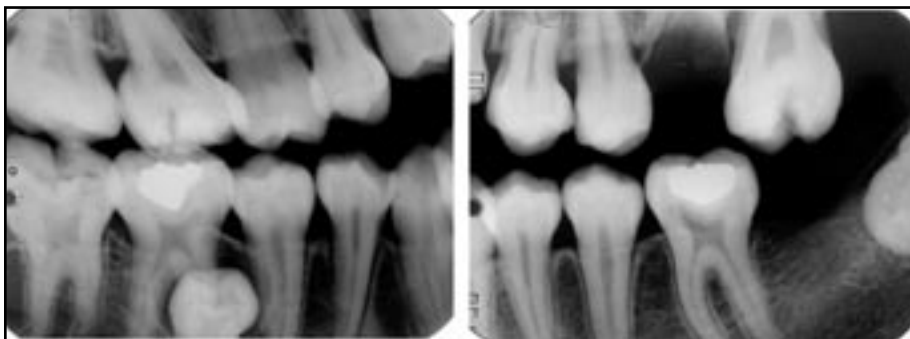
Bitewing radiographs at age 11 years showing severe destruction of the upper first left permanent molar's crown. A supernumerary tooth is visible near the mesial root of the right first permanent molar (arrow).
